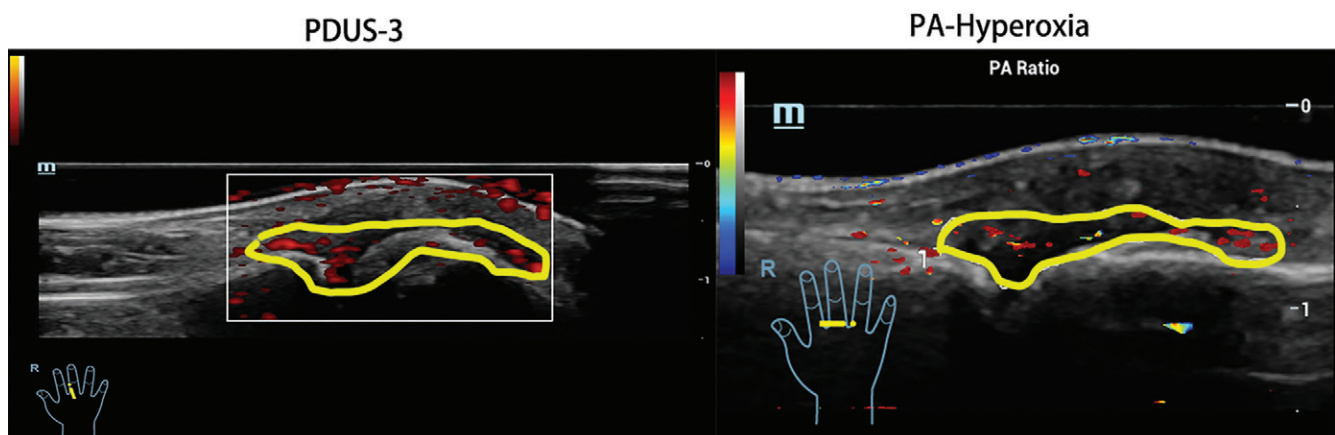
Example of power Doppler US (PDUS)–depicted hypervascularity and photoacoustic (PA) imaging–detected hyperoxia. The longitudinal section of (left) PDUS and (right) photoacoustic oxygenation saturation (SO_2) images in the right (R) third metacarpophalangeal joint of a 36-year-old woman, who had lived with rheumatoid arthritis for 4 years and experienced joint swelling and pain, show the joint had a PDUS grade 3 (abundant signals in more than half of the synovium; circled, left) and the PA- SO_2 mapping was red-dominant (circled, right), identified as hyperoxia. Imaging settings: luminous flux, less than 20 mJ/cm^2 ; fluctuation, less than 5%; imaging gain value, 45–55 dB; color bar, 40%–100%. For image scoring methods, see Appendix E1 (online).
